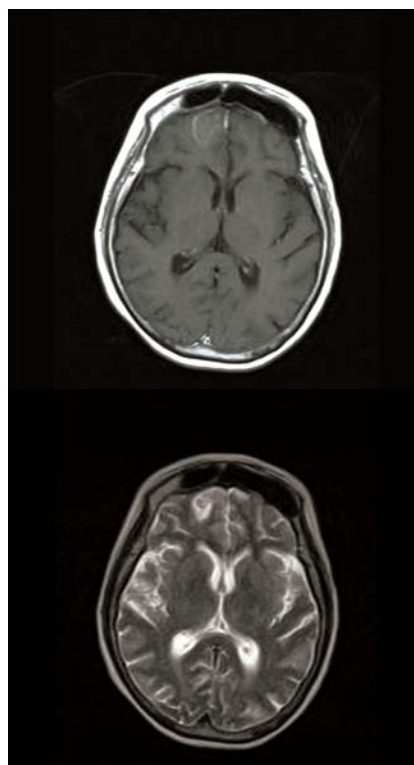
Preoperative T1-weighted axial MRI with contrast infusion (A), and preoperative T2-weighted axial MRI (B) showing the right frontal brain abscess.
